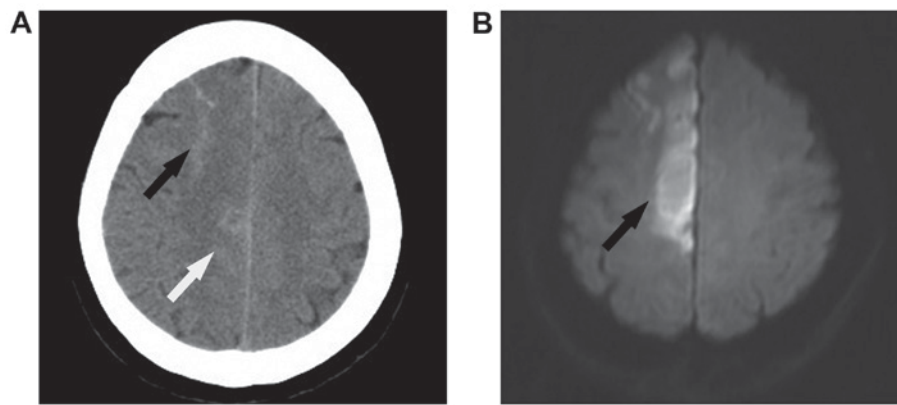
(A) On day 1 after onset, computed tomography demonstrated subarachnoid hemorrhage in the right superior frontal sulcus (black arrow) and right interhemispheric fissure (white arrow). (B) On day 2 after onset, diffusion weighted imaging sequences of magnetic resonance imaging showed hyperintense lesions in the territory of the right anterior cerebral artery (black arrow).
